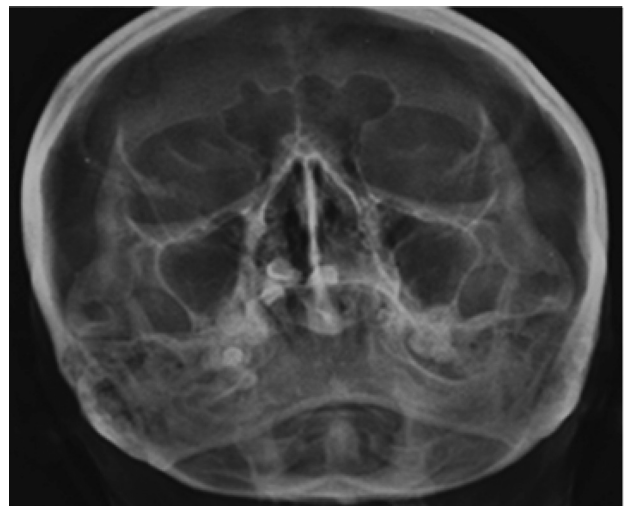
Preoperative radiograph showing a radio-opaque lesion within the right nasal cavity
